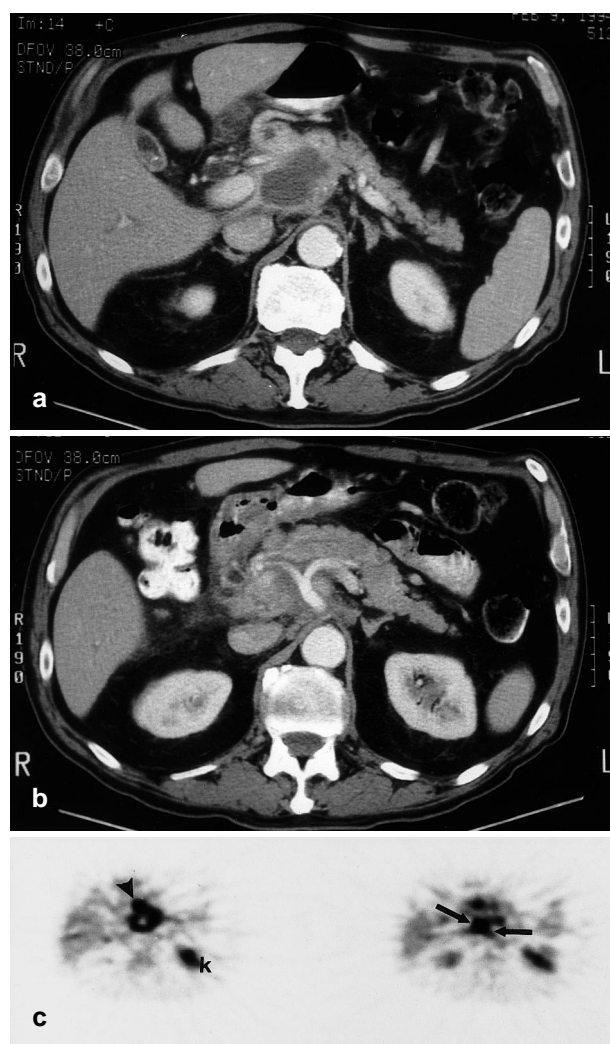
Mass-forming pancreatitis with pseudocyst formation and vessel encasement. Patient presented with abdominal pain and biliary tract obstruction and normal serum amylase and lipase. a,b Contrast-enhanced CT shows a pancreatic head mass with central low attenuation, an enlarged parapancreatic lymph node, and encasement of the celiac axis and superior mesenteric artery. c FDG PET at corresponding transaxial levels shows intense FDG accumulation (SUV = 9.8) in the mass surrounding an ametabolic center, and in an enlarged parapancreatic lymph node (*arrowhead*) and soft tissue vessel encasement (*arrows*). *k* denotes renal urinary tracer
